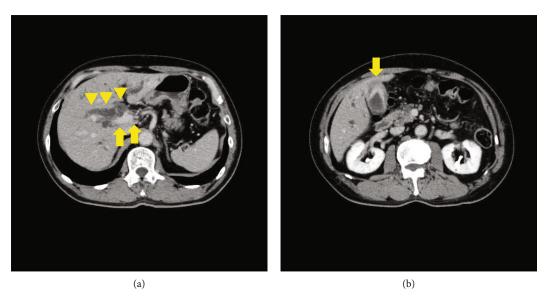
Enhanced CT findings. (a) A well-defined tumor from a cystic duct to a distal bile duct was observed (yellow arrow), and a hepatic-sided bile duct seen from the tumor was dilated. (b) Gallbladder mucosa was well-contrasted, and the wall was thickened (yellow arrow). CT: computed tomography.
